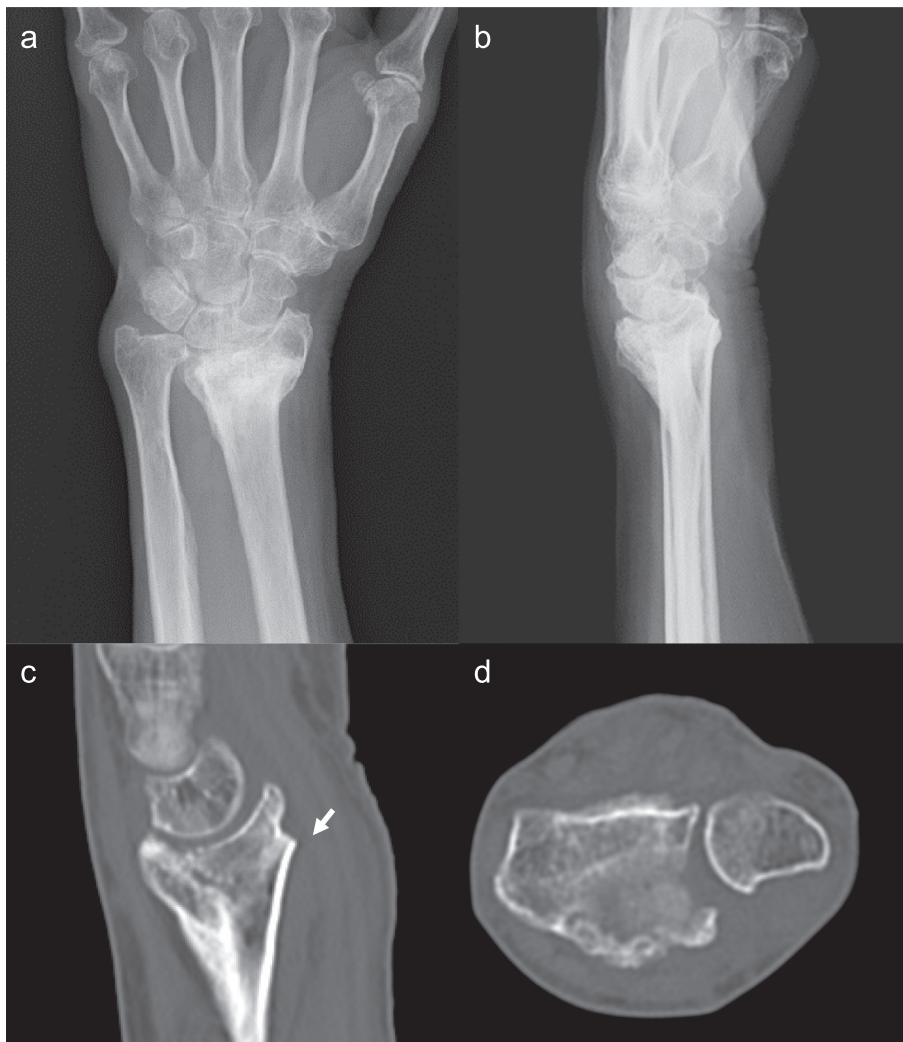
a and b Posteroanterior and lateral view radiographs of the left wrist of the Case 1, showing dorsally malunited distal radius fracture with 25° of dorsal tilt and 8 mm of positive ulnar variance. c Sagittal view CT of the left wrist, showing the bony prominence at the palmar surface of the distal radius (indicated by white arrow). d Axial view CT shows no palmar dislocation of the ulnar head.
